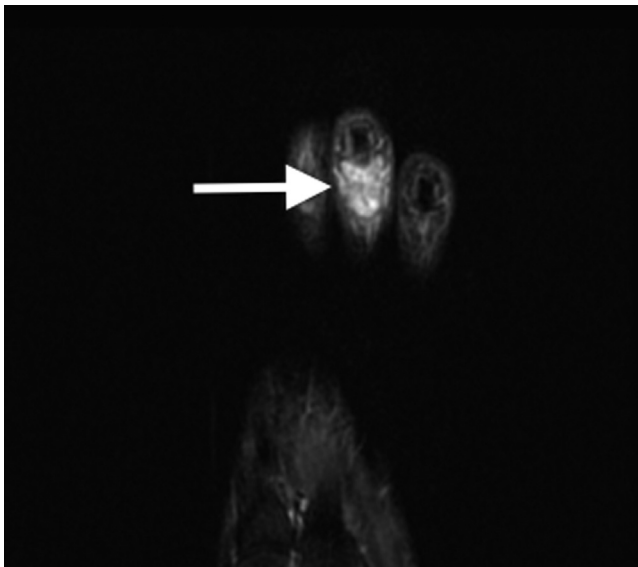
Fat suppressed magnetic resonance image showing an expansile hyperintense mass that has replaced much of the third middle phalanx (arrow).
